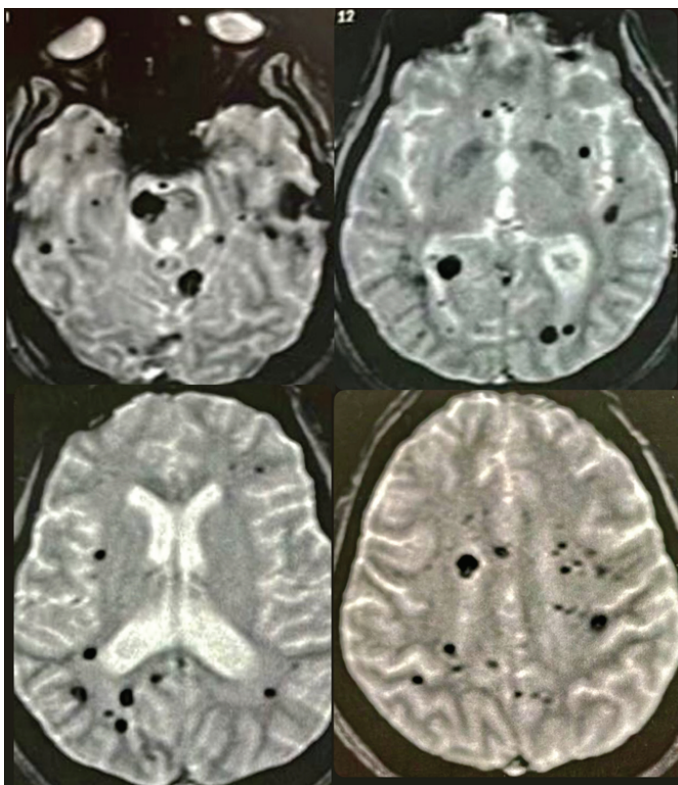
Axial brain MRI showing multiple isointense lesions without gadolinium enhancement in juxtacortical and deep brain regions, suggestive of multiple cavernomas.
